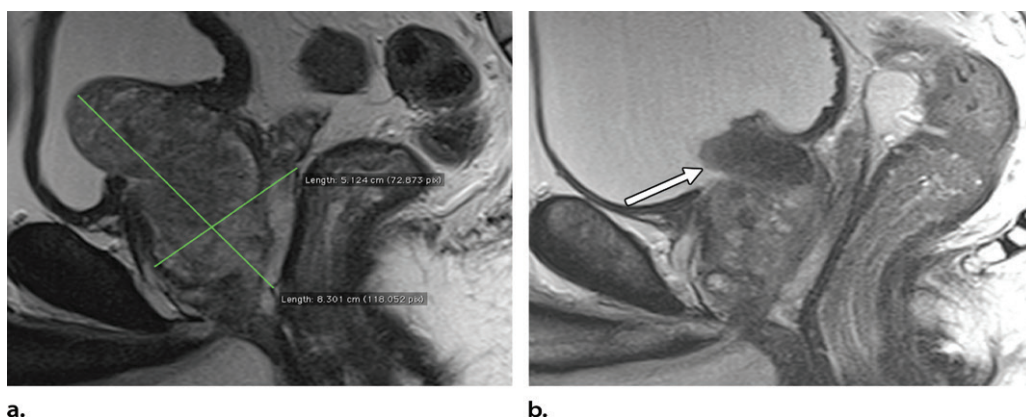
Sagittal T2-weighted MR images in a 70-year-old man show significant volume reduction after PAE, but a “ball-valve effect” of the middle lobe protrusion is causing a persistent infravesical obstruction (arrow in b) after infarction of the median lobe.
